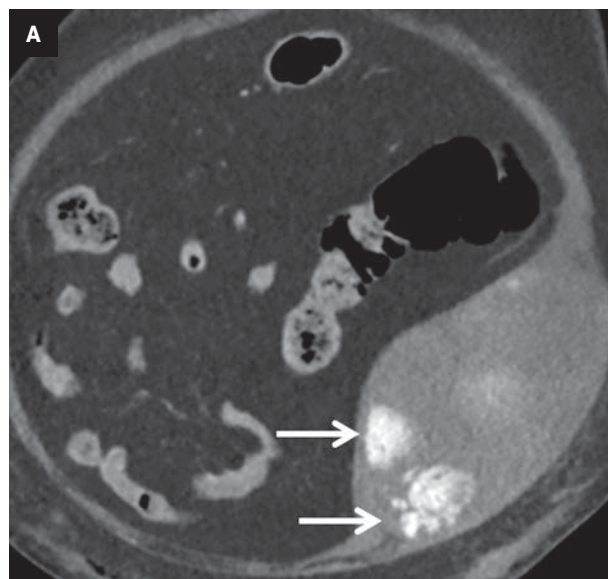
Oblique CT reformation (A) in a coagulopathic patient demonstrates foci of active bleeding in a left rectus sheath hematoma (white arrow). (B) Axial CT in the same patient demonstrates left psoas major hematoma (white arrow).
